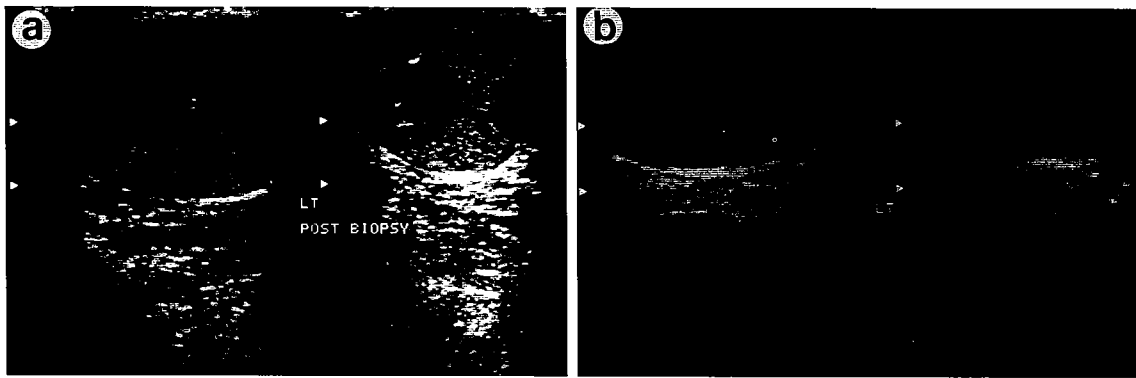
Ultrasound appearance of testis 30 minutes after percutaneous testis biopsy (a) and 2 weeks later (b). LT, left
